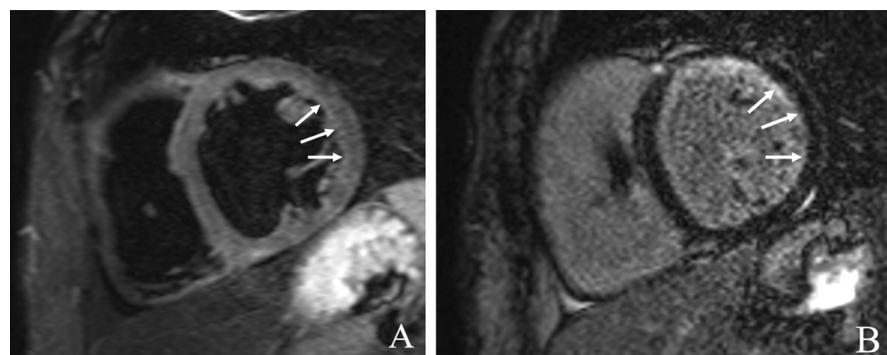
Cardiac MRI depicting myocarditis. (A) Short-axis dark blood T2-weight image shows thin subendocardial increased signal (arrows) suggestive of oedema. (B) Short-axis post-contrast late gadolinium enhancement (LGE) image shows thin subendocardial enhancement (arrows) suggestive of fibrosis or myonecrosis.
